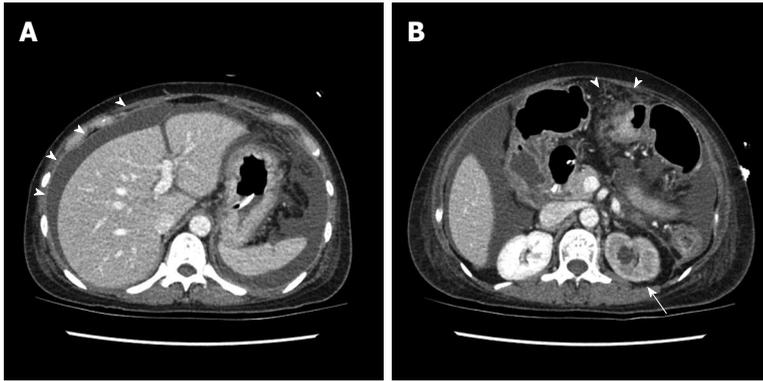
Peritoneal carcinomatosis in a 48-year-old female patient with advanced gastric cancer. A: Axial 2D CT image shows a large volume of ascites and peritoneal thickening (arrowheads); B: Axial 2D CT image at a lower level than (A) delineates ascites, omental infiltration and nodules (arrowheads), and hydronephrosis of the left kidney (arrow).
